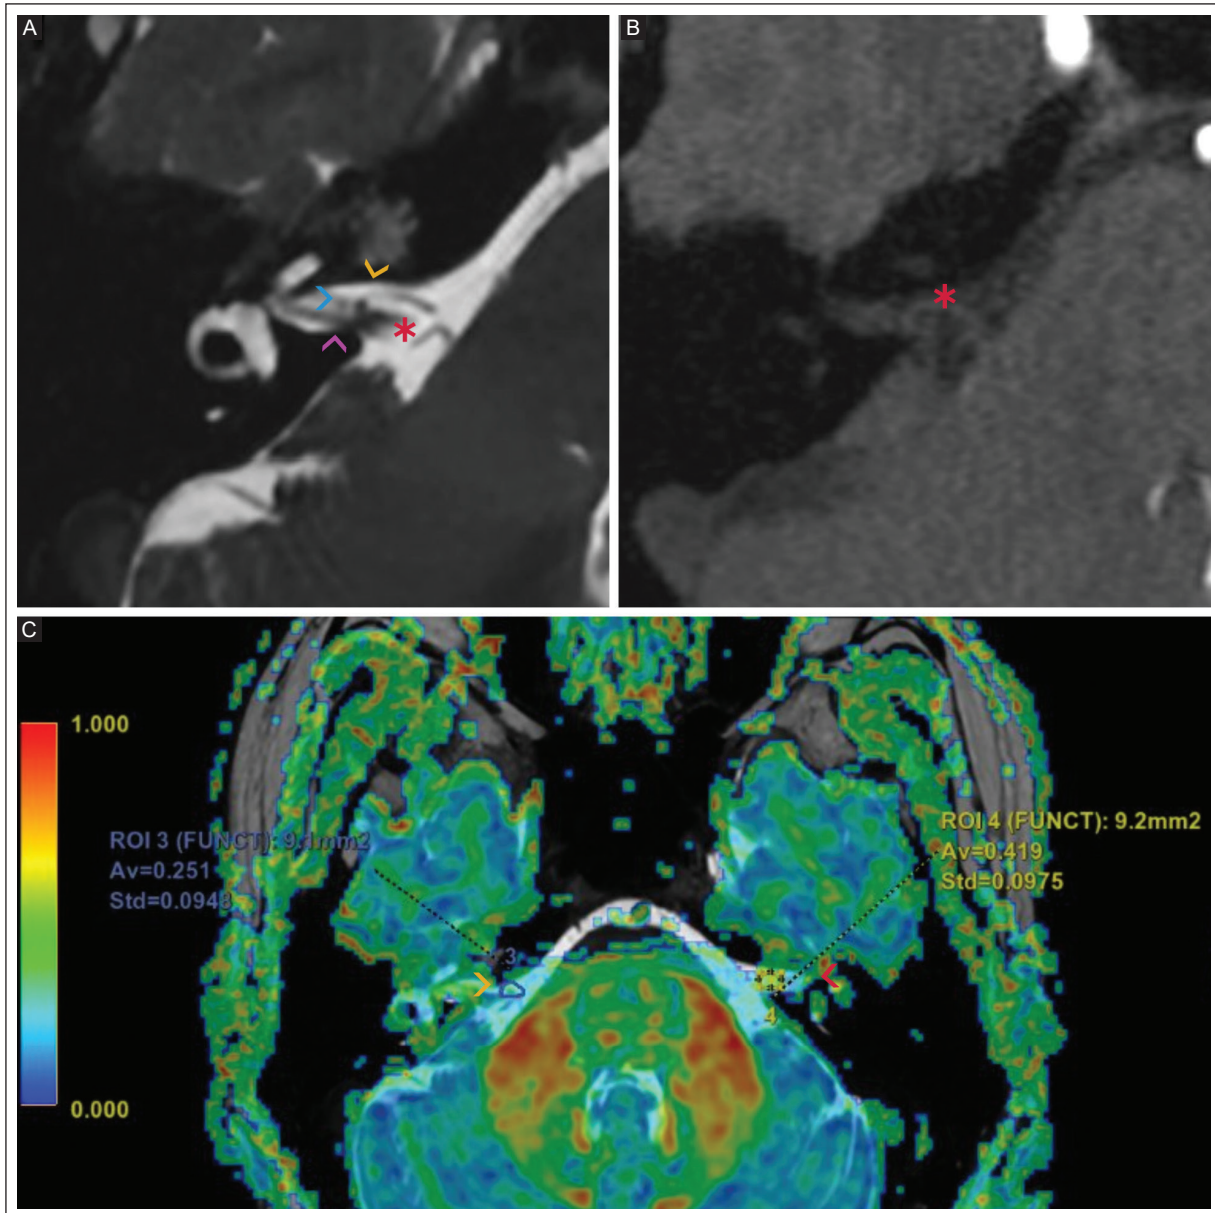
A 3.0T MRI of a 61-year-old man with tinnitus. A: the T2-weighted CUBE shows a right NVC Chavda type II (yellow arrowhead) with an anteroinferior cerebellar artery loop (asterisk) extending less than 50% into the internal auditory canal (purple arrowhead), adjacent to the nerve complex VII/VIII (blue arrowhead). B: a 3D-TOF shows an anteroinferior cerebellar artery loop (asterisk) in the internal auditory canal. C: a DTI T2 CUBE showing fusion with decreased FA of 0.251 in the ROI at the level of the NVC (yellow arrowhead). The contralateral ear shows FA of 0.419 (red arrowhead).
